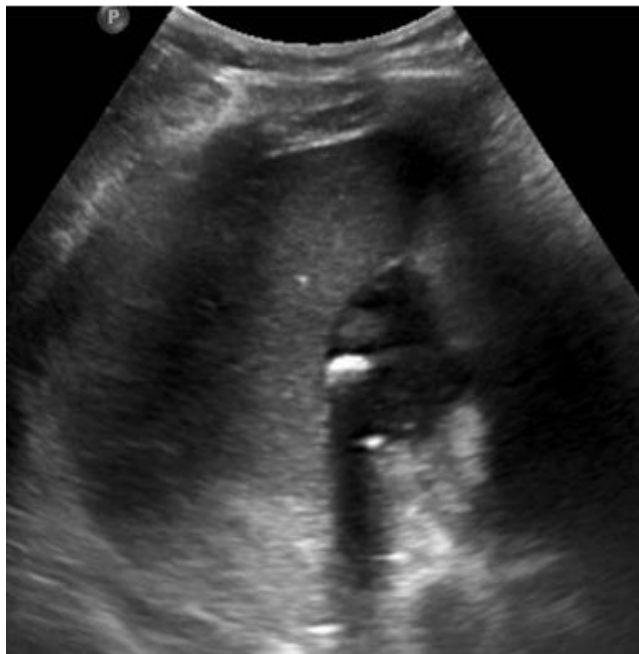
Ultrasound image showing collection (15-20cc) with few extra luminal calculi (largest calculus measuring 8-9mm adjacent to gall bladder).
